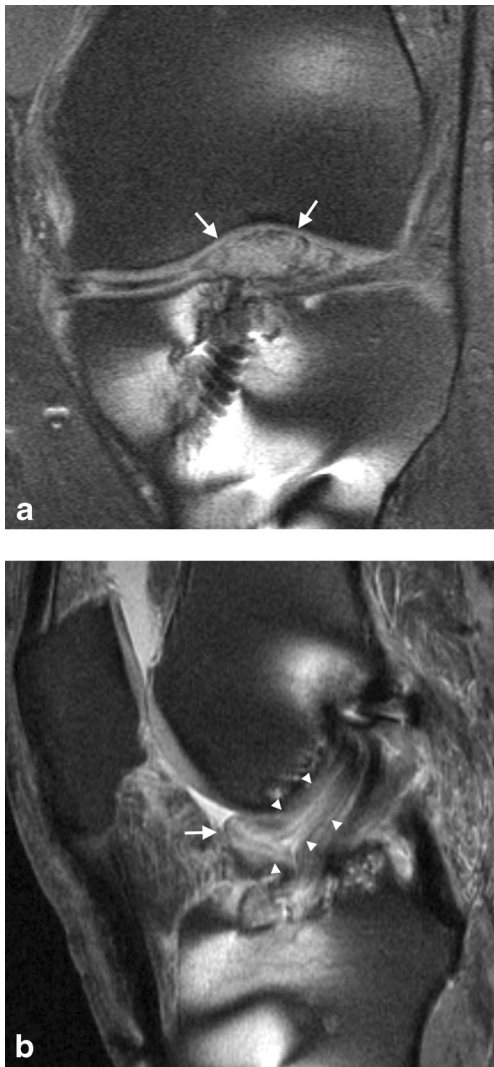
A 50-year-old male with previous ACL reconstruction using a patellar tendon autograft. a Coronal and b sagittal PD-weighted fat-saturated MR images (TR 2,840, TE 14 and TR 4,590, TE 17, respectively) demonstrate the intermediate signal intensity nodule, i.e., “pseudocyclops” (arrow), in the anterior intercondylar notch with the displaced graft fibers extending directly from the femoral and tibial tunnels (arrowheads)
